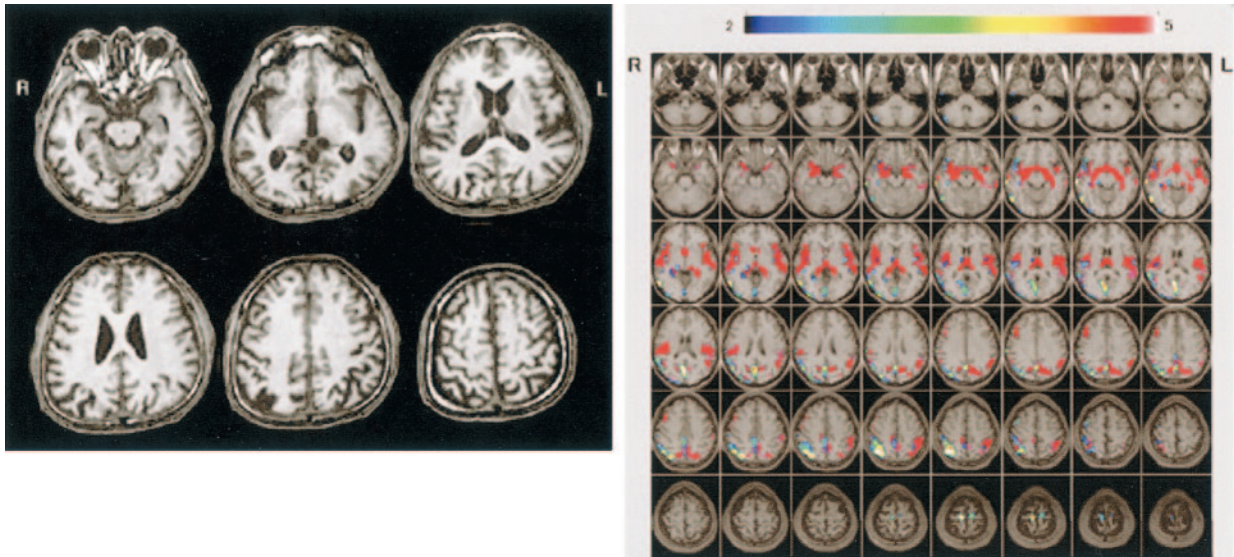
A and B, Conventional MR images (A) and Z score images (B) obtained in a 54-year-old patient with early-onset AD (MMSE score = 23). Mild right parietal lobular atrophy can be detected by visual inspection of the conventional T1-weighted images; however, the degree of atrophy was not estimated. By using the Z score map, the region and degree of atrophy can be detected easily, enabling this case to be diagnosed as AD. Areas with Z scores greater than 2 (indicated by rainbow color scale) in this subject were overlaid on the prototypic early-onset AD template map (overlaid on normal MR images with red area). L indicates left; R, right.
